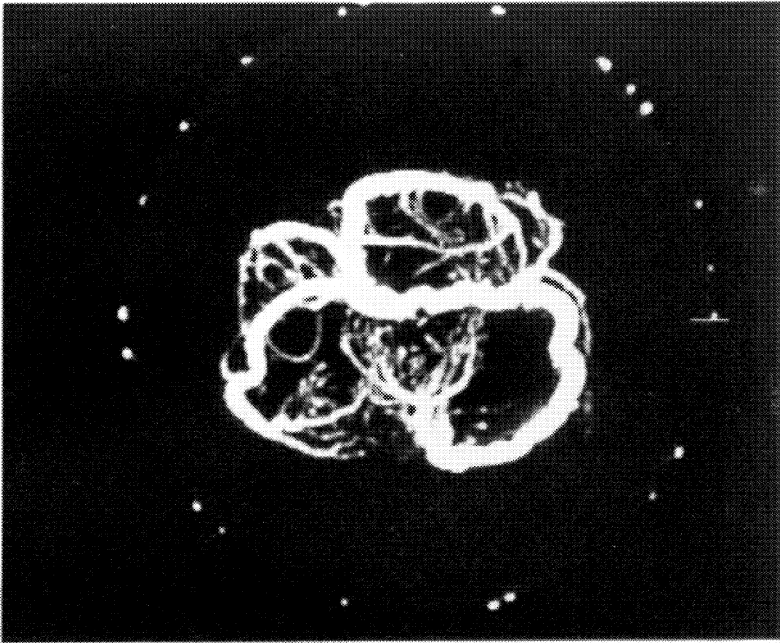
(a) A projection image through the set of axial CT images. (b) same as (a) with points representing the 3D reconstruction added.
